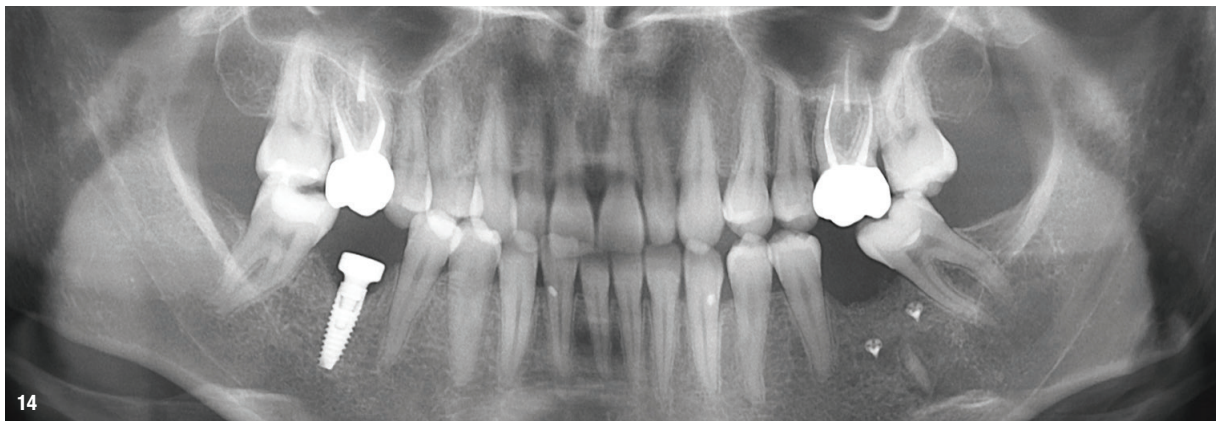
Panoramic radiograph to confirm the implant position.
